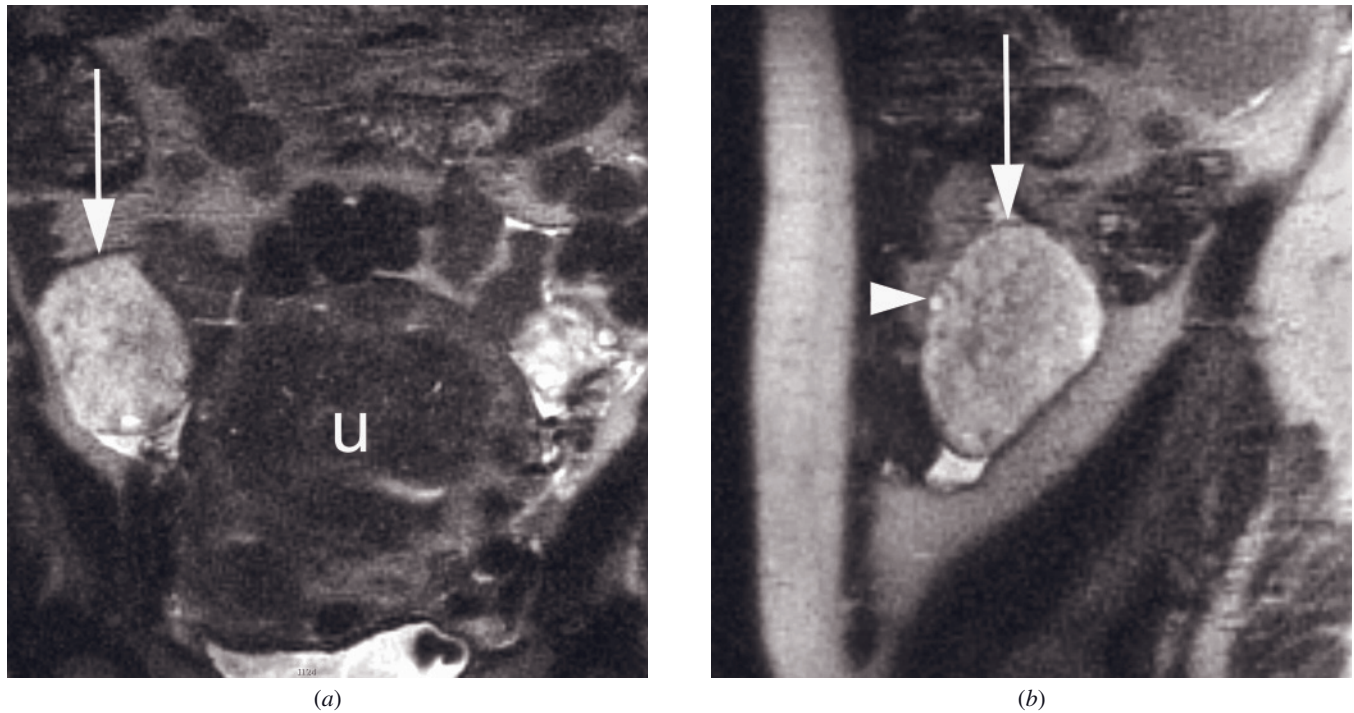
Massive ovarian edema. Coronal (*a*) and sagittal (*b*) T2-weighted SS-ETSE images show an enlarged right ovary (arrow, *a, b*) with increased stromal signal intensity and few small peripheral follicles (arrowhead, *b*). Note the enlarged uterus (*u, a*) due to adenomyosis and leiomyomata.
